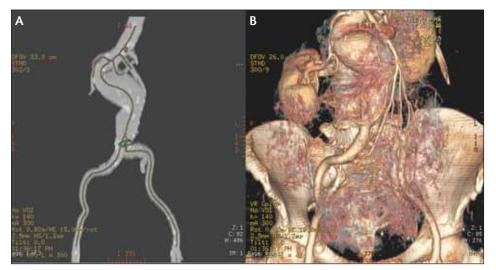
Three-dimensional reconstructions and maximum intensity projections allow for better case planning (A). This three-dimensional computed tomographic (CT) angiogram demonstrates difficult proximal neck anatomy (B). Visualization before the procedure improves patient outcomes. In this particular patient, the left arm was prepped for a "body floss" technique to straighten out the neck and allow safe delivery of the endoprosthesis.
